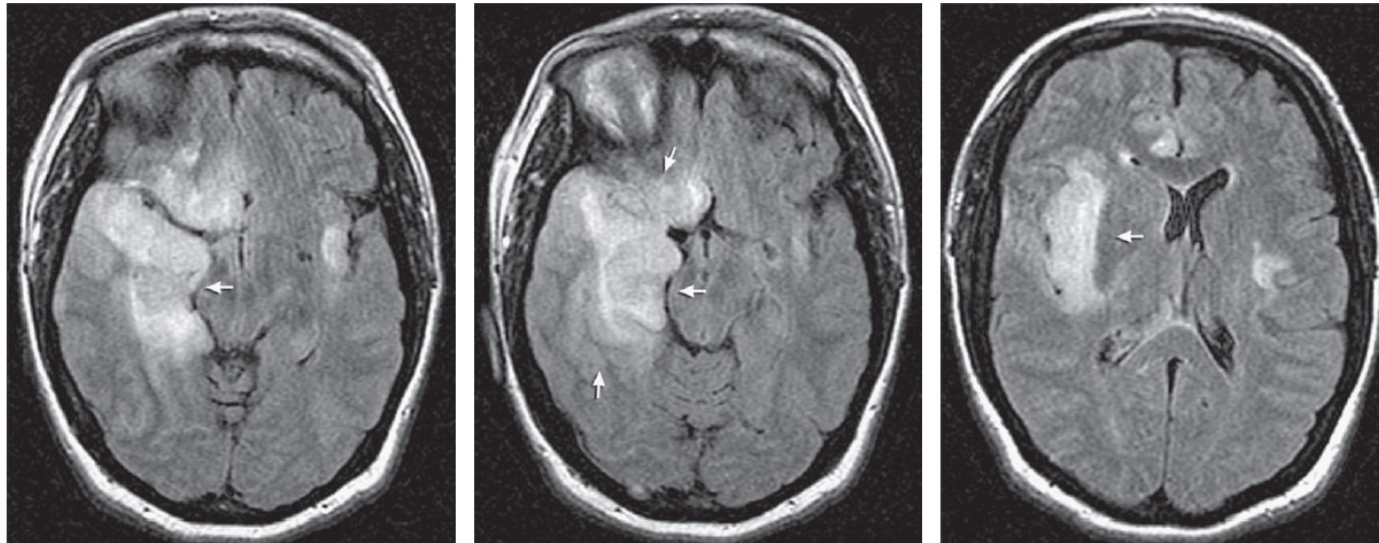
Herpes simplex encephalitis. Magnetic resonance images with typical hyperintensities in temporal, frontal lobe, and insular regions (*arrows*).
